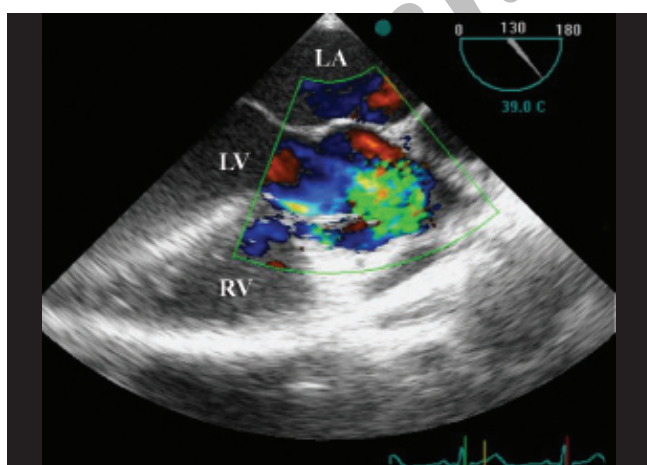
Color Doppler imaging demonstrating the flow within the echo lucent space and connection between that and left ventricle (LV)
